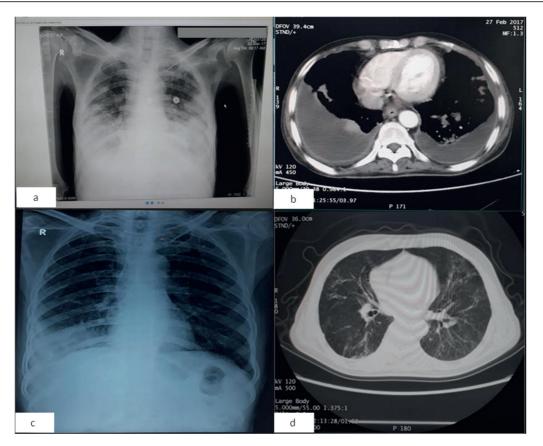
a: Chest radiolgraph frontal view showing B/L mid basal haziness with obscured CP angles. b: axial CECT mediastinal window showing B/L pleural effusion with posterobasal dependent consolidation. c: Chest radiograph showing patchy haziness in B/L (Rt > Lt) with obscured CP angles. d: Axial CT lung window showing patchy cosolidation with interstitial thickening.
